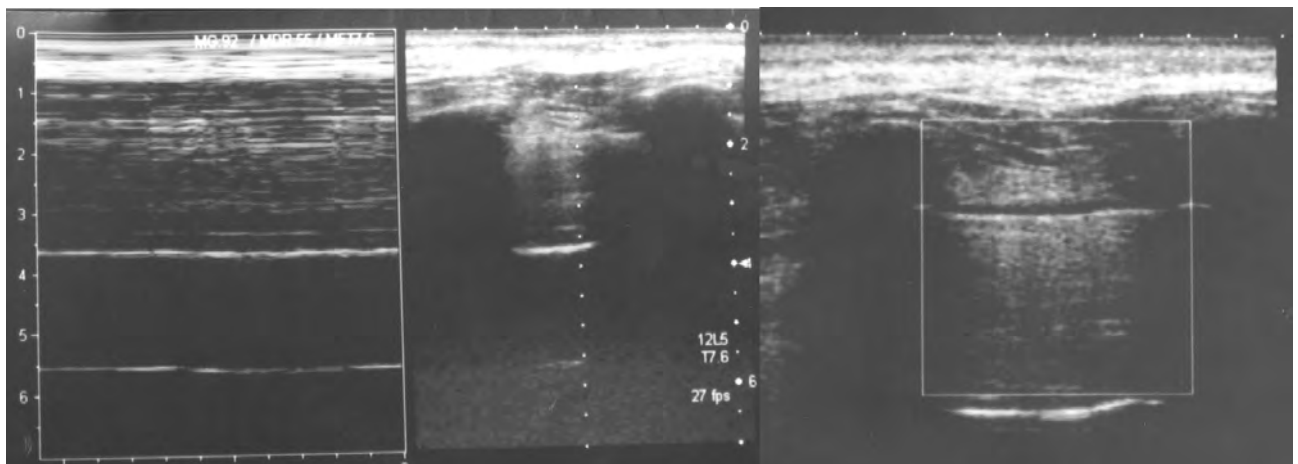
Chest ultrasound image showing no pleural sliding, suggestive of left pneumothorax.
